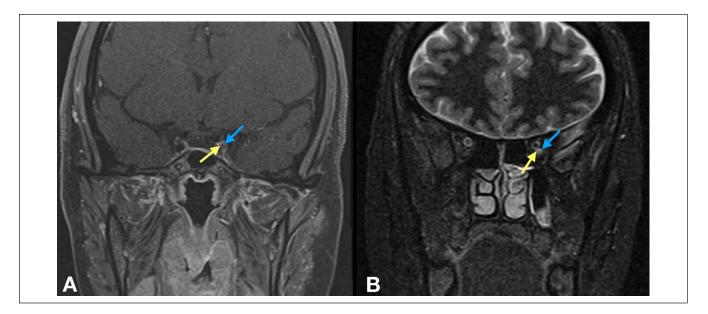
MRI Brain and Orbits showing asymmetrical thickeing and enhancement of the left oculomotor nerve.
